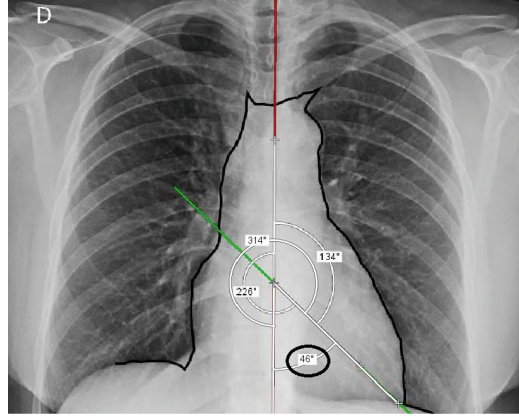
Application of the Icy program on the chest x-ray image to estimate the angle of inclination of the heart.
